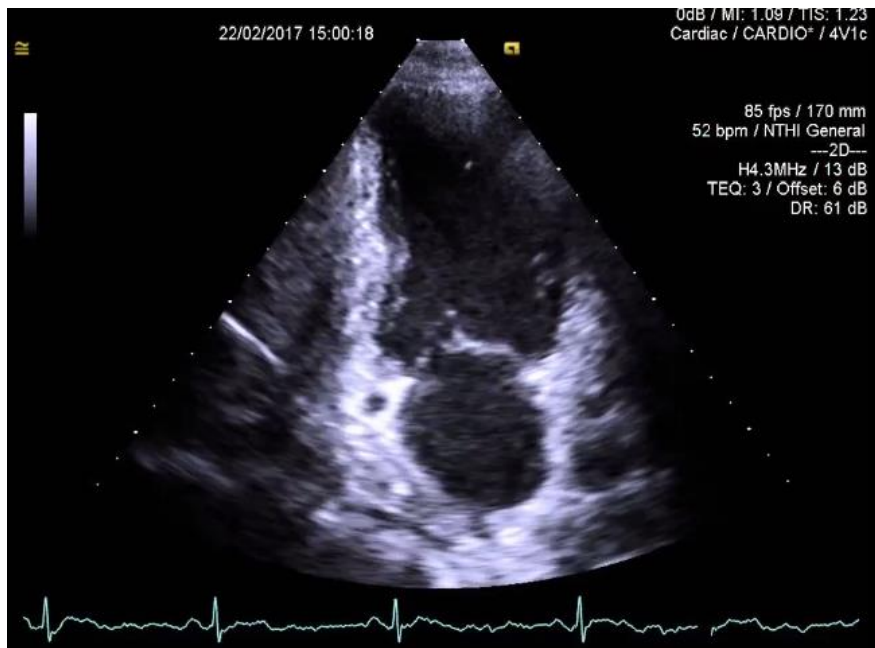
Apical two-chamber view.
